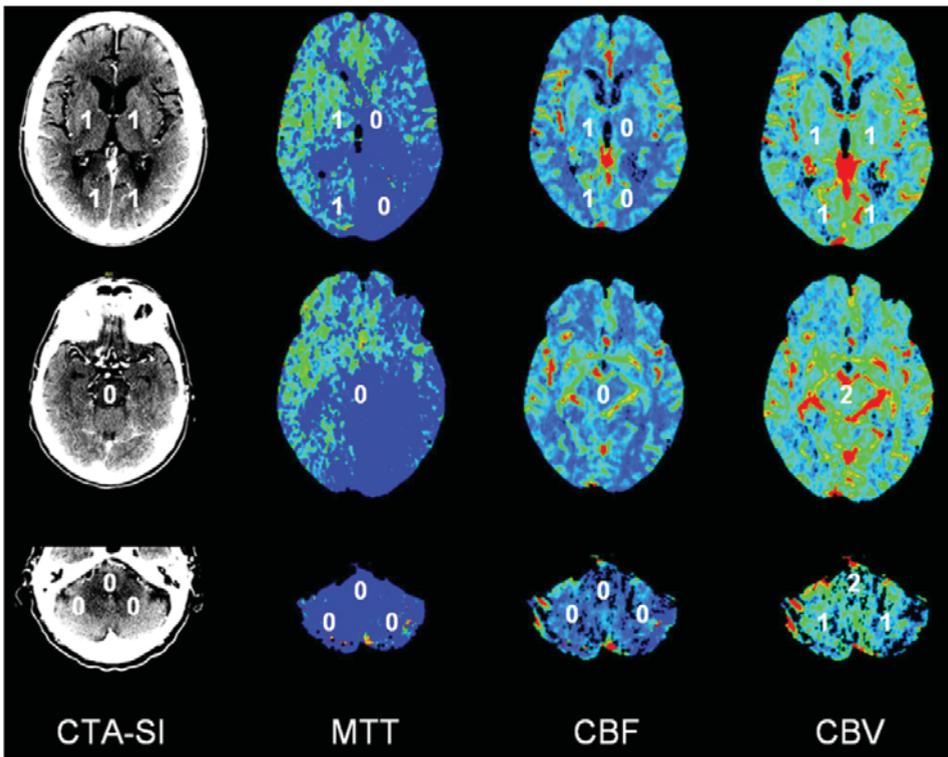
Example of the application of pc-ASPECTS to CTA-SI and CTP parameter maps in a 73-year-old male from the BASICS registry (baseline NIHSS score 7, acute treatment with IV heparin only; complete recanalization of the basilar artery on follow-up CTA after 24 hours; mRS score of 1 at 1 month). The first column shows CTA-SI with hypoattenuation in the pons, midbrain, and cerebellum with a resulting pc-ASPECTS score of 6. The second column (MTT) demonstrates MTT delay in the left thalamus, left PCA territory, midbrain, pons and cerebellum resulting in a pc-ASPECTS score of 2. MTT is also mildly increased in the left middle cerebral artery territory due to pre-existing carotid artery stenosis. The third column (CBF) displays CBF delay in the same pattern as MTT (pc-ASPECTS score 2). CBV parameter maps demonstrate no decreased CBV, thus resulting in a pc-ASPECTS score of 10.
